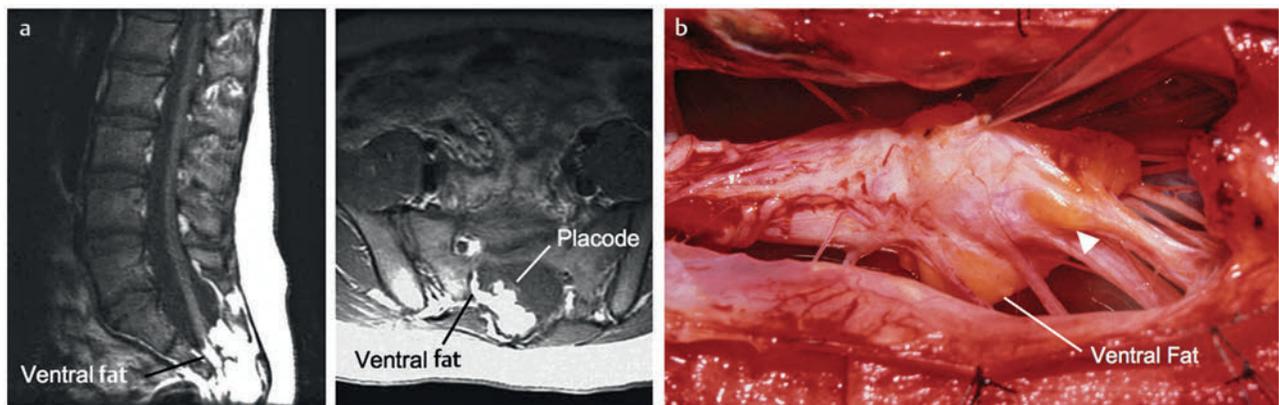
Chaotic lipoma. (a) Sagittal magnetic resonance image shows ventral as well as dorsal fat in relation to the neural placode. Note sacral agenesis, with only two visible sacral segments. Axial image shows ventral fat and an extremely irregular lipoma-fat interface. (b) Intraoperative picture showing fat ventral to the placode and on one of the sacral roots (arrowhead). Note absence of a discrete fusion line.
